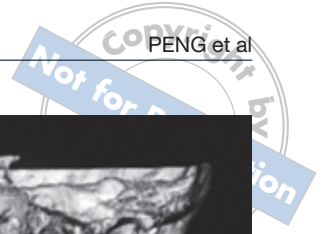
3D-CT showed an elongated left styloid process measuring 8.5 cm.
